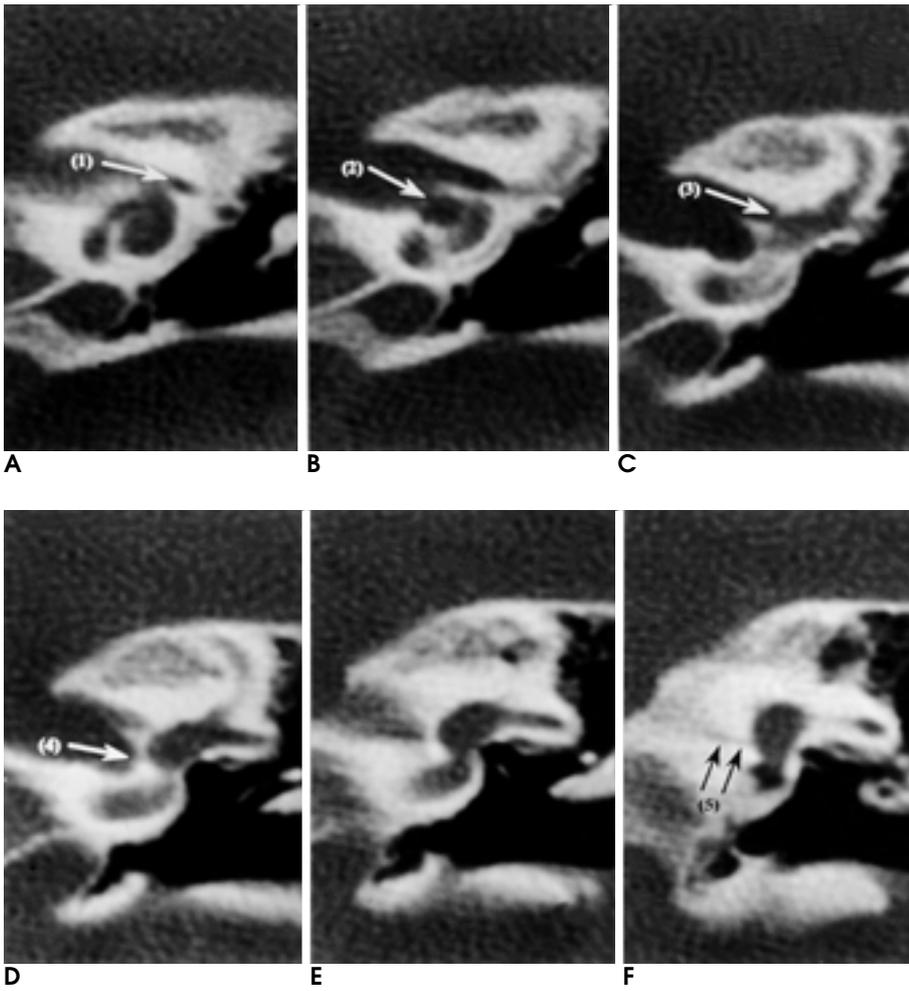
A-F. Serial contiguous coronal images of high-resolution temporal CT with edge-algorithm. Arrows indicate bony canals for labyrinthine segment of facial nerve (1), cochlear nerve (2), superior vestibular nerve (3), saccular branch (4) and posterior ampullary nerve (5) of inferior vestibular nerve.
